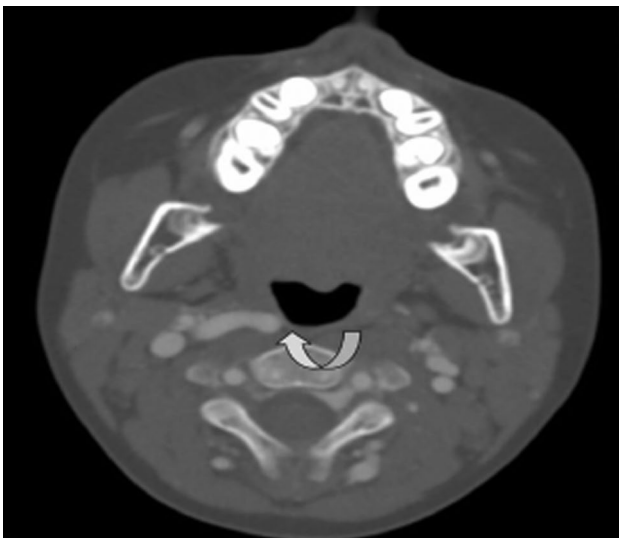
Axial section of the cervical computed tomography angiography. Window level at the bone preset. The tortuosity of the internal carotid artery on the lateral pharyngeal wall is seen (curved arrow).
